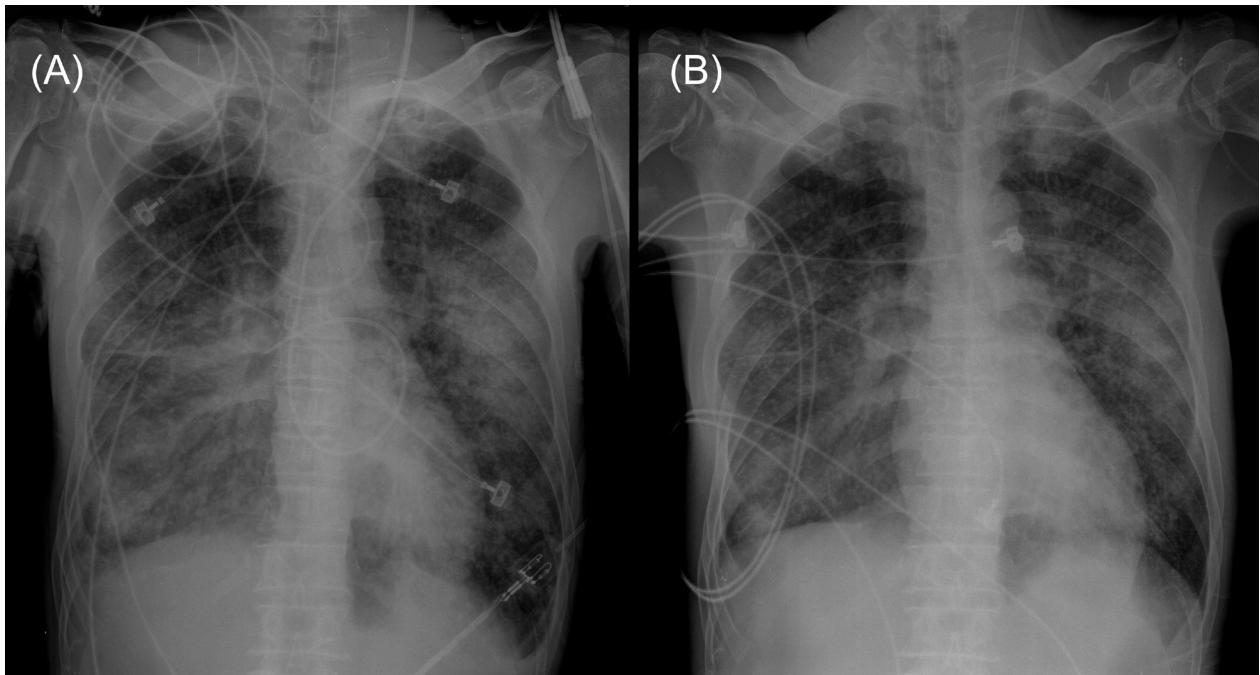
(A) Chest radiograph showing bilateral alveolar infiltration with diffuse micronodules on admission; (B) Chest radiograph showing improvement 2 days after treatment with intravenous immunoglobulin.
